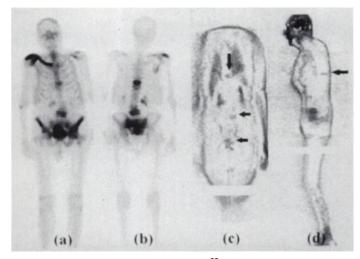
(A) Anterior and (B) posterior ⁹⁹mTc-MDP bone scans show increased uptake in several bones affected by Paget's disease in a patient previously treated with disodium pamidronate. (C) Coronal and (D) sagittal [¹⁸F]FDG PET slices showing only mildly increased uptake of tracer in lower thoracic and lumbar vertebrae and sacrum (arrows). Other bones shown to be affected on ^{99m}Tc-MDP bone scan showed no abnormality with [¹⁸F]FDG PET.
